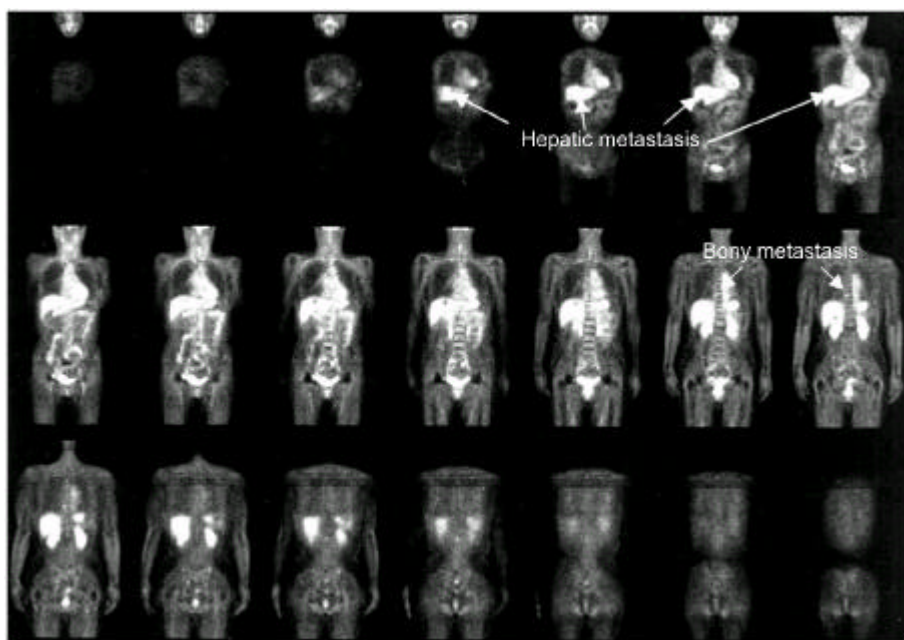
FDG-PET finding of bony and hepatic metastasis. A 55 old female was operated modified radical mastectomy for right breast cancer with stage IIb at September, 1999. She was examined PET at November, 2001 because bony and hepatic metastases were suspicious on bone scan and liver computed tomography. Anterior coronal FDG-PET cuts revealed intense hypermetabolic foci at thoracic spine and liver (arrows), consistent with bony and hepatic metastases. The clinicoradiologic follow-up confirmed that she had bony and hepatic metastases.
